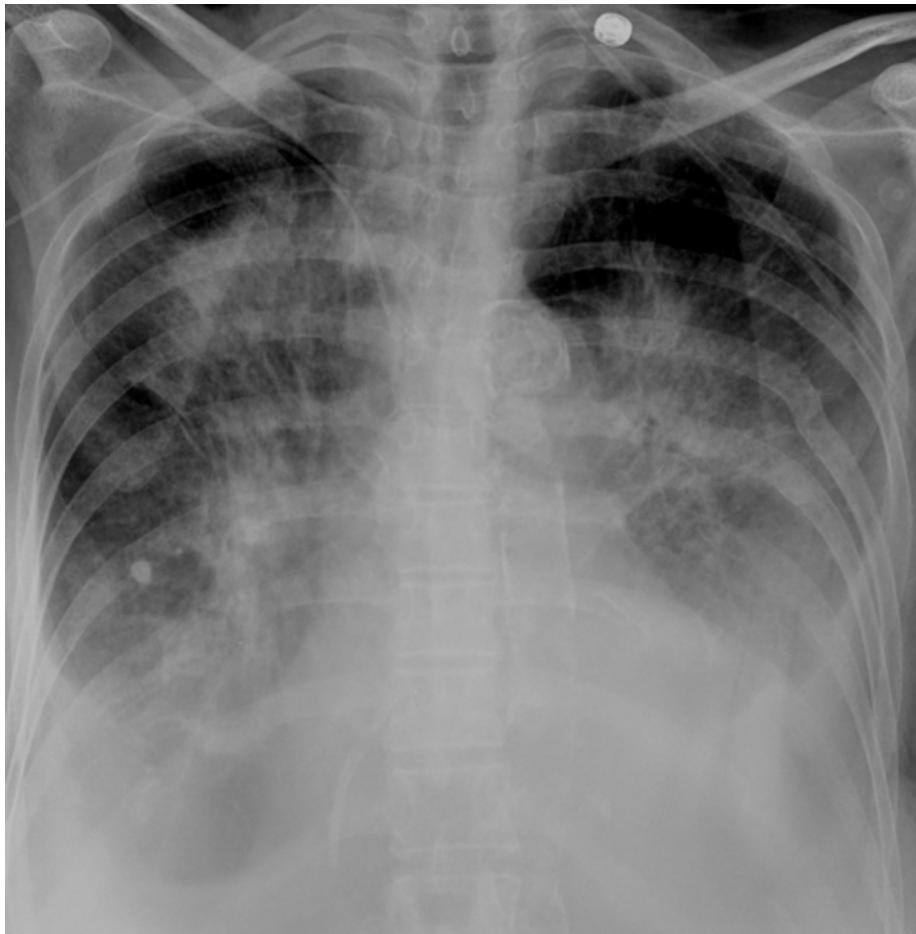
Over-penetrated radiograph. Notice how unusually well the vertebral bodies are seen through the heart. The problem with over-penetration is evident in the lung fields, where detail of the parenchymal process is lost because of the poor technique.
